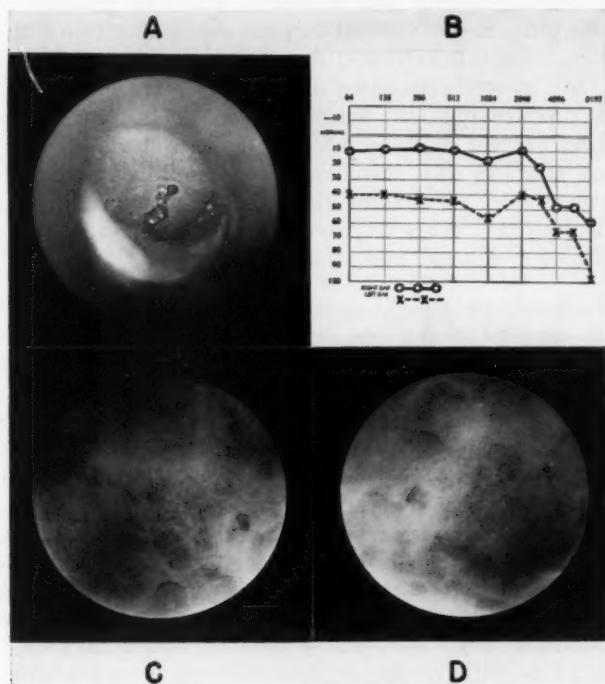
(A) Appearance of the left drum membrane of a 38-year-old male with painless onset of discharge two months before. The ears were seen to be normal when he was examined for tuberculous laryngitis three months before. Culture negative for *M. tuberculosis*. (B) Audiogram of same patient. (C) The right and (D) the left mastoid X-ray. Both are well pneumatized, normal.
